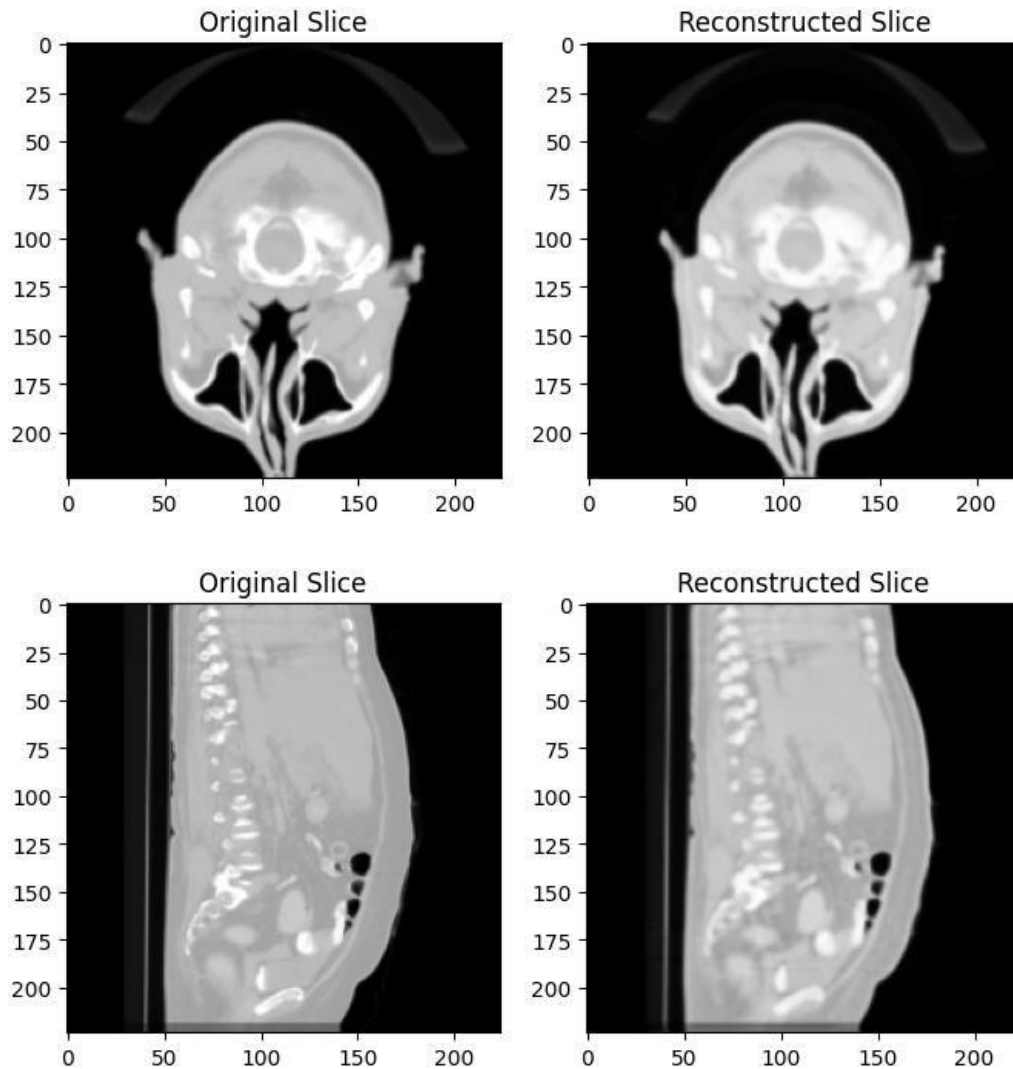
Axial Slice Comparison Between Original and Reconstructed CT Volumes
